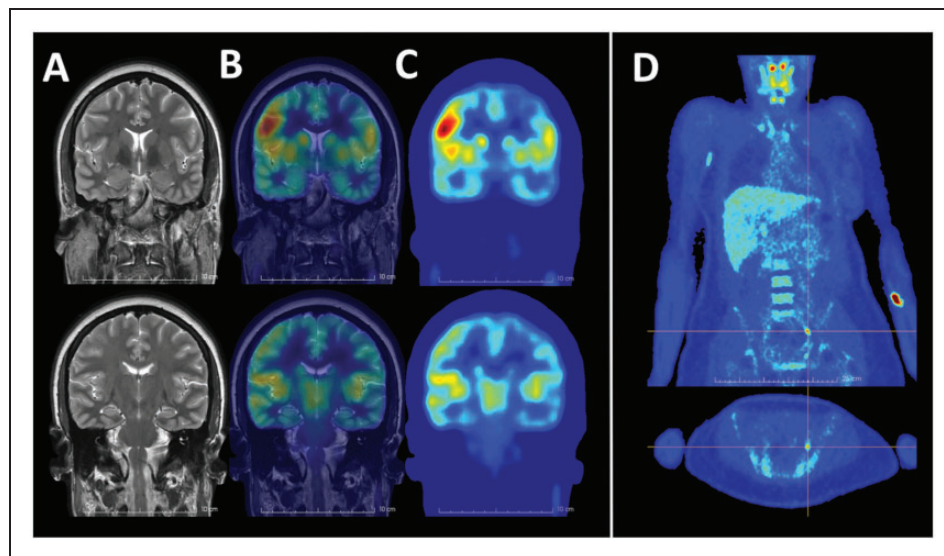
Coronal T2-weighted MRI (a) of the patient showing subtle cortical thickening in the right hemisphere most prominently in the temporal lobe. T2-weighted MRI images superimposed with FDG-PET (b) and source FDG-PET (c) images showing right frontal hypermetabolism with asymmetric metabolic activities in the temporal lobes and hypometabolism without obvious MRI correlate. Coronal and axial views of whole-body PET scan (d) revealing a small hypermetabolic left ovarian mass consistent with the teratoma. MRI: magnetic resonance imaging; FDG-PET: fluorodeoxyglucose positron emission tomography.
